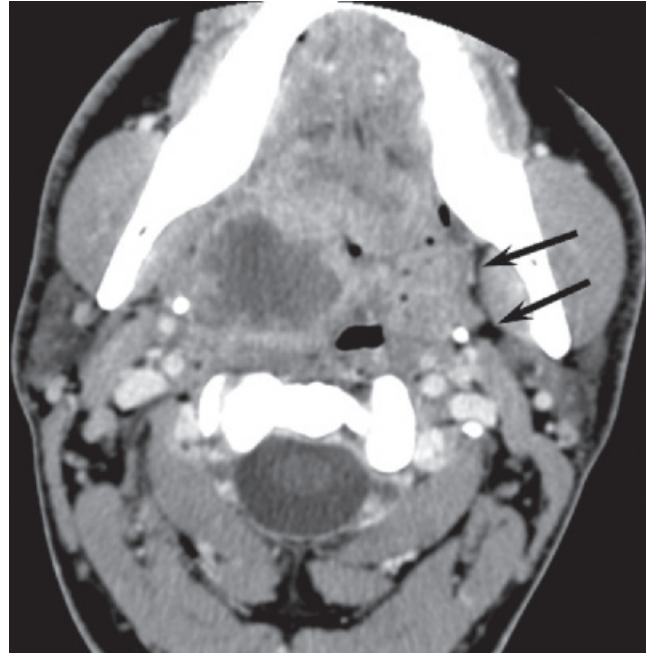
Parapharyngeal abscess. Axial contrast-enhanced CT shows a large abscess involving both the peritonsillar space and the parapharyngeal space, with replacement of the parapharyngeal fat. The abscess extends laterally to the styloid process. The normal contralateral parapharyngeal fat is still visible (*arrows*).
